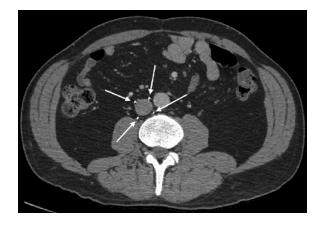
Single-slice axial contrast-enhanced CT image of the abdomen at the level of the inferior mesenteric artery origin demonstrating perforation of the 4 inferior tynes through the caval wall. No involvement of the vital adjacent structures by the tynes is seen.
